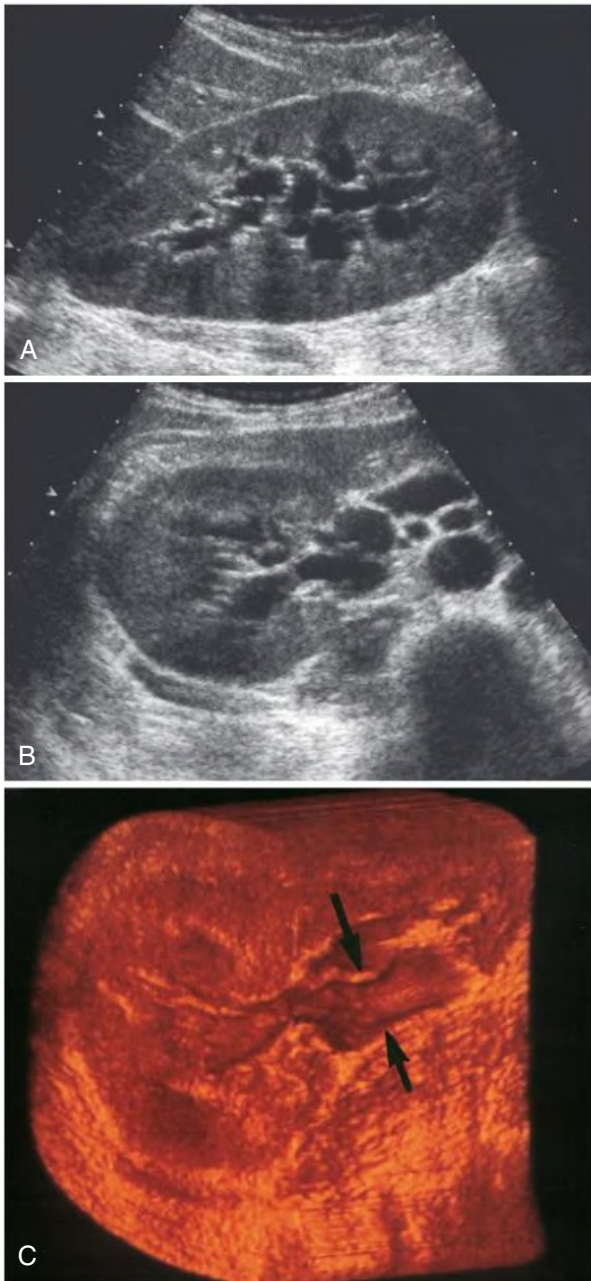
Kidney Ultrasound Study Demonstrating Hydronephrosis. (A) Sagittal ultrasound image. (B) Transverse image. (C) Transverse three-dimensional surface-rendered image. Arrows indicate the dilated proximal ureter.
